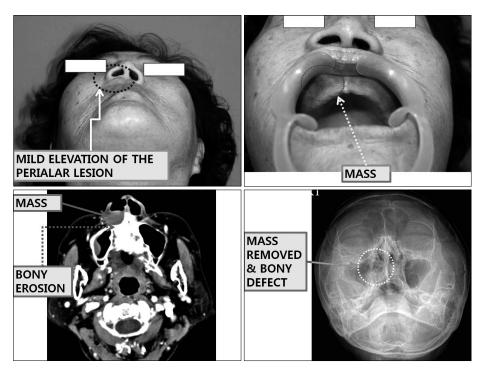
Case 2. A 64-year-old female. (Above, left) Preoperatively, there is mild elevation of the right peri-alar region. (Above, right) The mass is seen in the right gingivobuccal area. (Below, left) Preoperative enhanced axial CT shows a well-defined, ovoid, soft-tissue cystic lesion $(1 \times 1 \times 1.5 \text{ cm})$ with bony involvement. (Below, right) A simple x-ray obtained immediately postoperatively reveals maxillary indentation.
